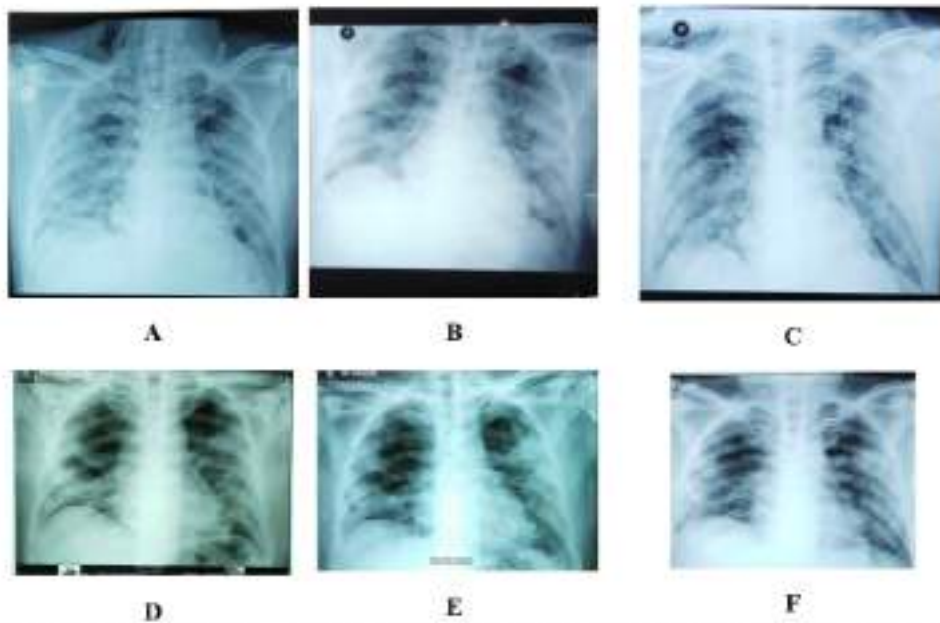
Serial Chest Radiograph Showed A Slow Improvement (A-F). A. 15 March 2020 (Illness Day 12, Hospital Day 6); B. 16 March 2020 (Illness Day 13, Hospital Day 7); C. 19 March 2020 (Illness Day 16, Hospital Day 10); D. 27 March 2020 (Illness Day 24, Hospital Day 18); E. 30 March 2020 (Illness Day 27, Hospital Day 19); F. 2 April (Illness Day 30, Hospital Day 22).
